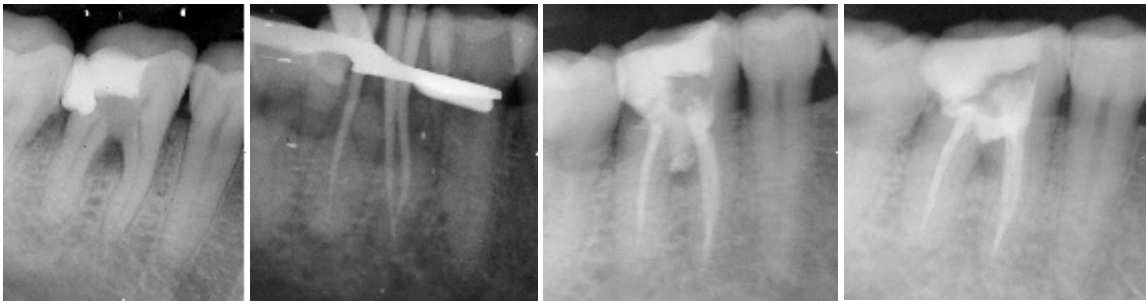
Periapical image of tooth 46 showing inadvertent furcal perforation, caused by drilling during access preparation for root canal treatment.
